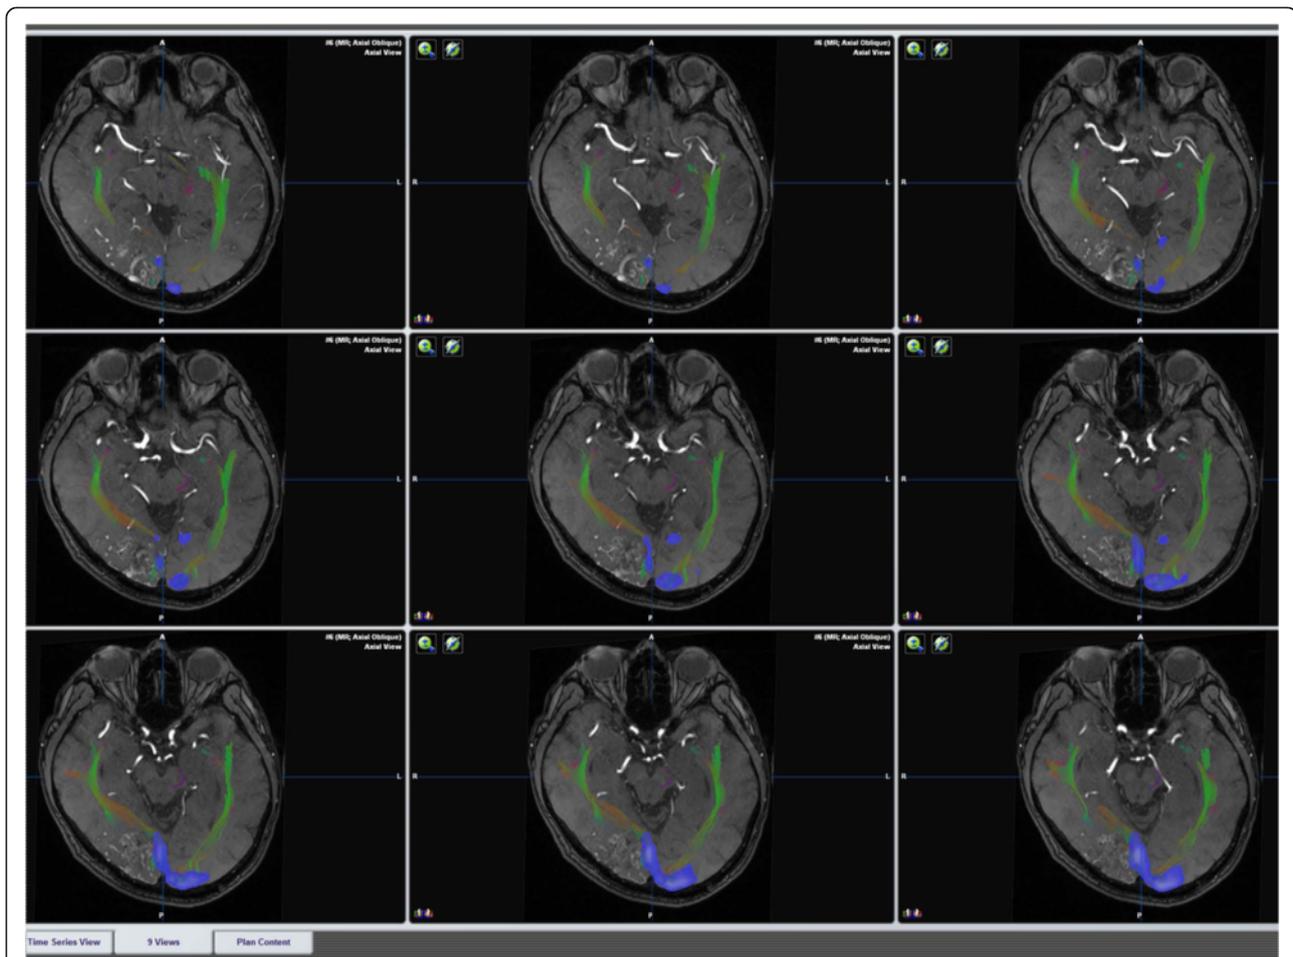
Case 38. A 36-year-old male with a history of sustained epilepsy. Enhanced structural axial T1-weighted image showing a right occipital AVM. Based on enhanced structural axial T1-weighted image, fiber tracking showing the asymmetry of optic radiation (*green*) and visual cortex (*blue*). Both the AVM-OR and AVM-VC distances were zero
